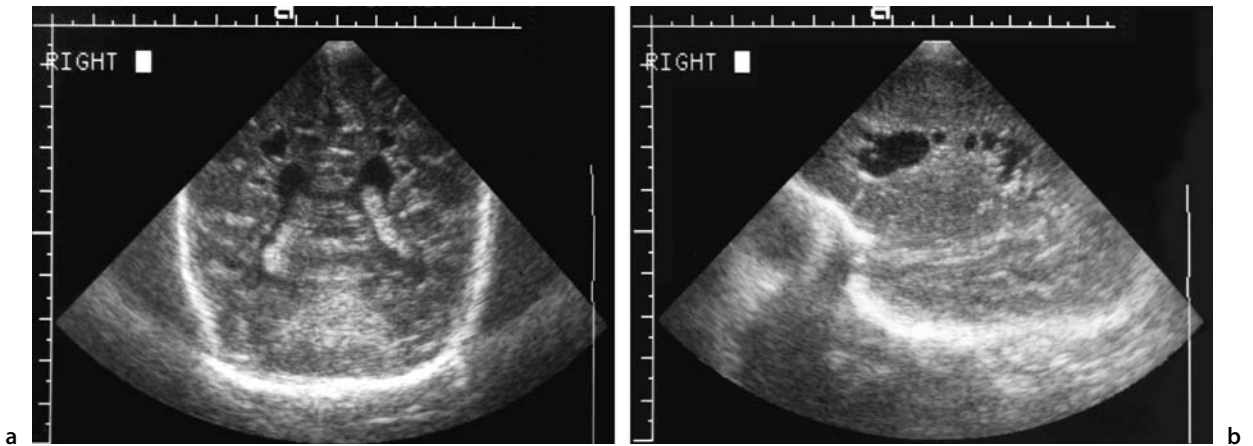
Ultrasound of a premature (26 weeks' gestation) infant at 4 weeks of age. Coronal (a) and sagittal (b) images of this neonate reveal multiple cavities (black holes) surrounding the ventricle. This represents ischemic disease called periventricular leukomalacia
